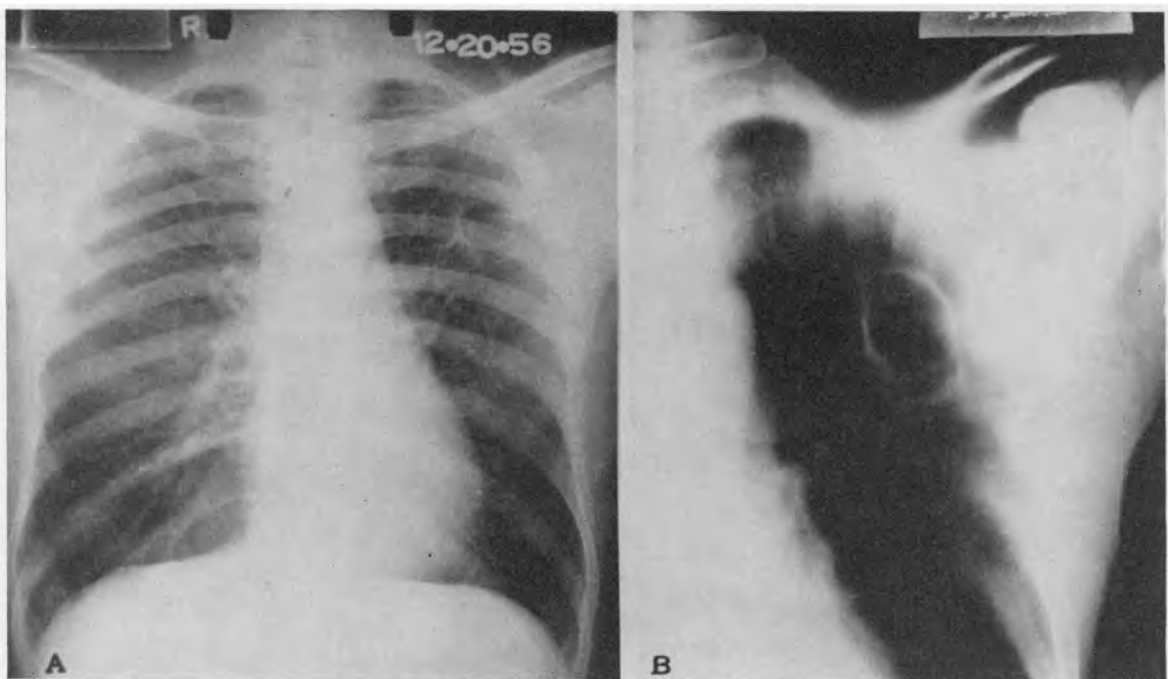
Roentgenogram of the Chest on Admission (A) in Case 2, Showing a Cavity in the Left Upper Lobe, and Planigram (B), Showing the Thin-Walled Cavity.
